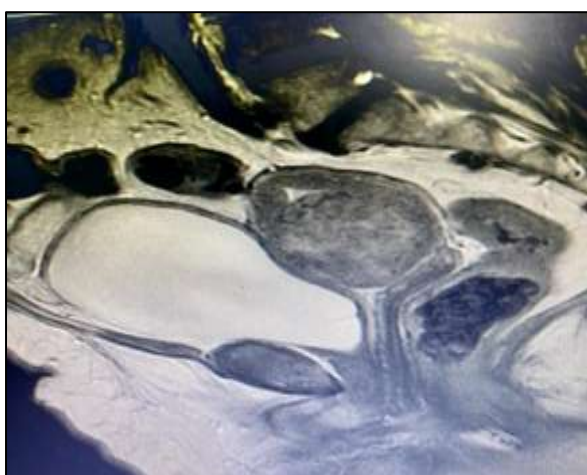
A close up of MRI pelvis showing fibroid uterus (FIGO 2-5) pushing the endometrium.
